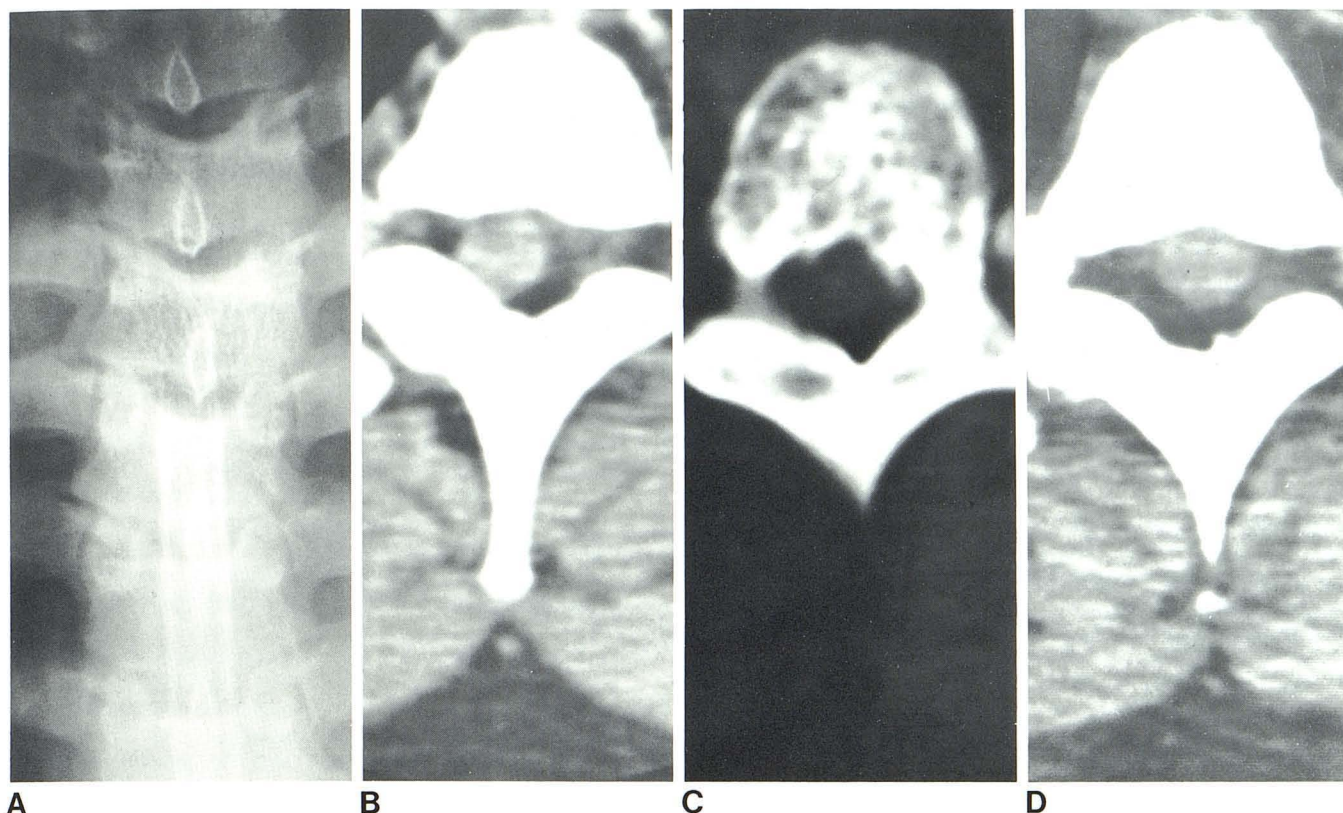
Case 3. A, Metrizamide myelogram. Complete extradural block at upper T5 level. Discrete vertical striations at T4 and possibly T3 vertebral bodies suggest hemangiomas. B, Metrizamide CT at T4–T5 level. Right-sided displacement of enhanced dural sac by poorly defined lesion on the left. C, CT scan at T4 level using wide window settings. Irregularly thickened trabeculae consistent with hemangioma. D, CT scan at T4–T5 level 1 month later. Midline dural sac and complete resolution of left-sided mass lesion.
